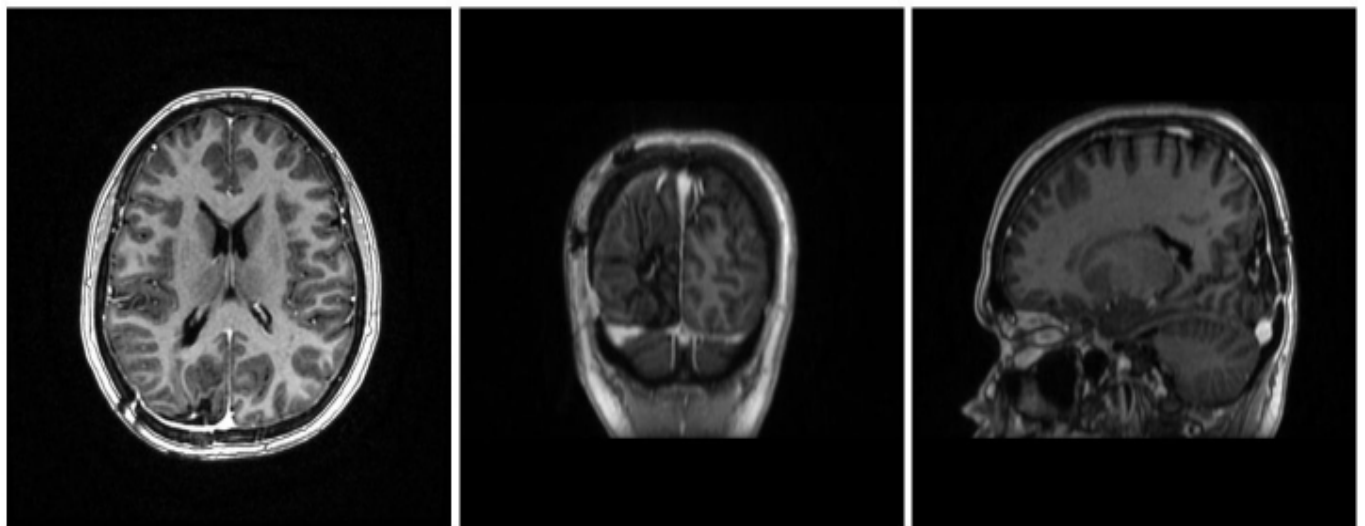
Contrast-enhanced MR images taken at the 10th postoperative month show encephalomalacia changes and peripheral gliosis in a location corresponding to the right posterior cerebral artery irrigation area.
